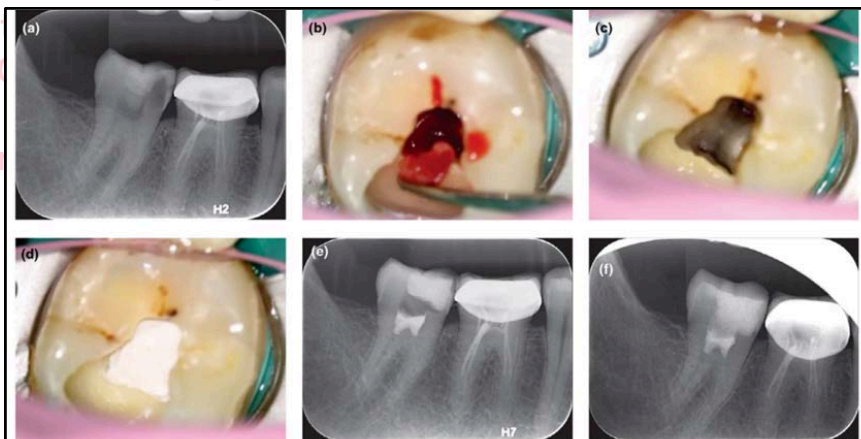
Right mandibular second molar (#47) had mesial caries into the pulp, in a 32-year-old man. (a) A preoperative PA radiograph. (b) A clinical photograph showing the pulp wound. (c). A clinical photograph showing haemostasis and bleeding control during the pulpotomy. (d) A clinical photograph showing capping of wound with iRoot BP Plus after full pulpotomy. (e) Immediate postoperative radiograph. (f) A PA radiograph at a 12-month follow-up. The tooth had been permanently restored.
